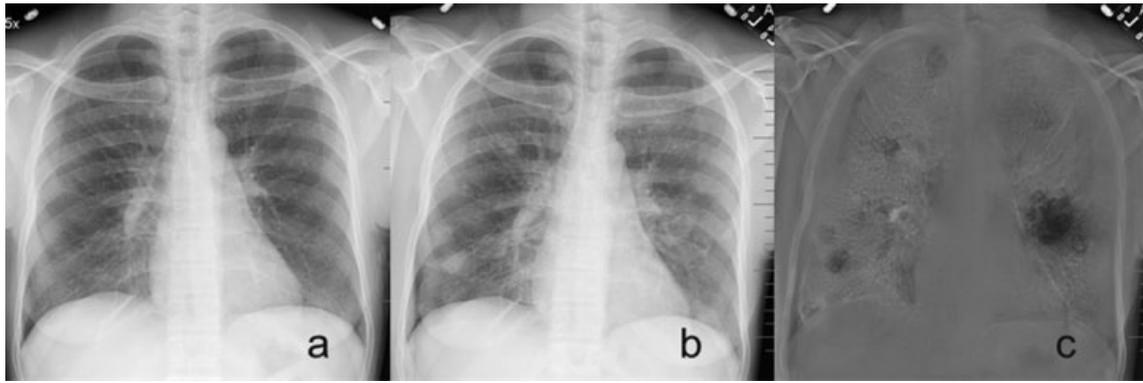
Previous radiograph (a) is registered to the current radiograph (b) and subtracted to generate a subtraction image (c) (Riverain Technologies, Miamisburg, OH). Bone suppressed images are used to improve the subtraction image. The subtraction image clearly reveals newly formed focal lesions in the left and right lung, while only minor misregistration artifacts of the ribs can be seen.
